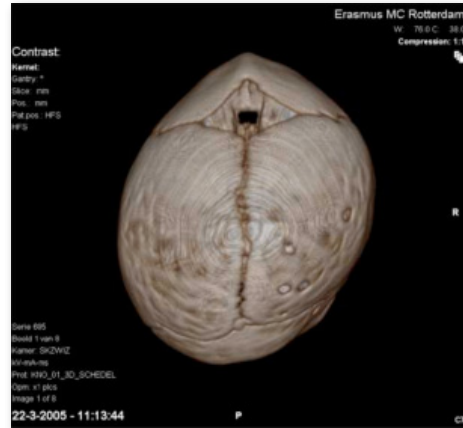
Preoperative 3D CT scan showing metopic synostosis and positional plagiocephaly.
